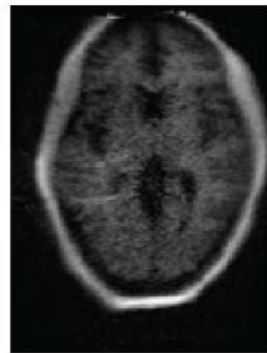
Portable Hyperfine 64 mT MR scanner Hyperfine Swoop, the world's first portable MR imaging system, is capable of providing neuroimaging at the point of care. Its capabilities enable timely diagnosis and treatment of acute conditions across various clinical settings.
